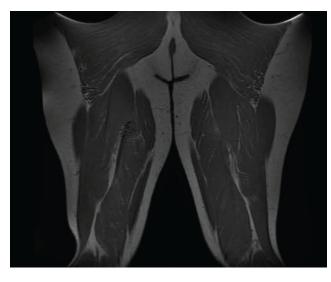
Repeat MRI Images (8 weeks post-operation)
